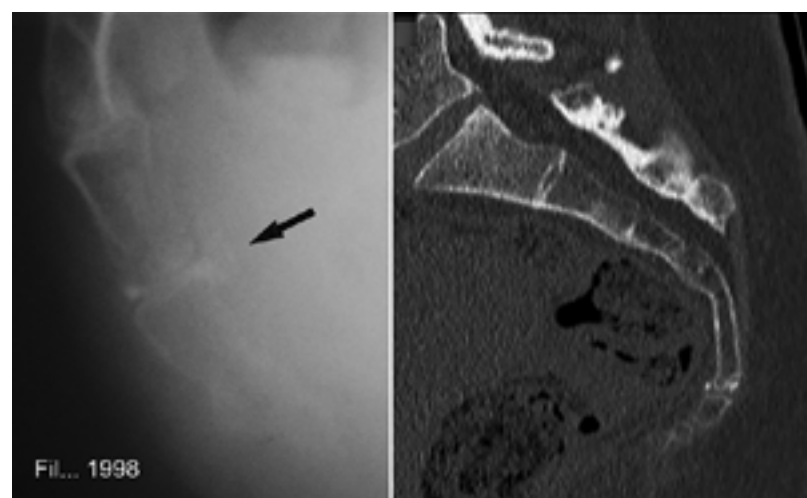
Appearance of ventral and dorsal calcification on x-ray and CT image. These are two different patients.
